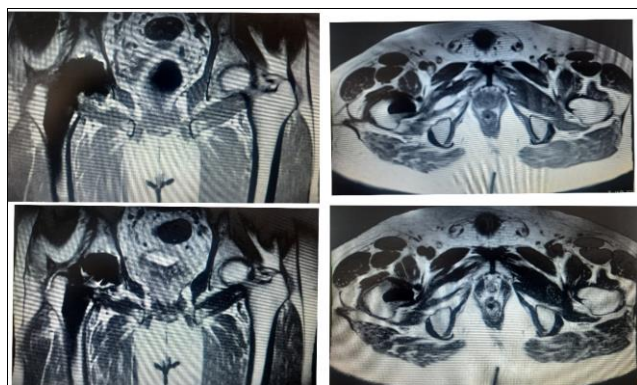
Post-operative MRI study depicting right THA
